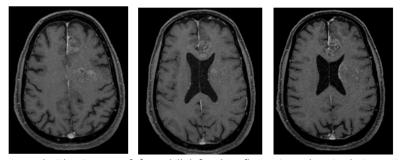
65 year old male presented with seizures: Left frontal ill defined confluent ring enhancing lesions with adjacent leptomeningeal enhancement. TB Vs mets with leptomeningeal spread was given as possibilities on MRI. The lesion turned out to be as metastasis from adenocarcinoma lung
